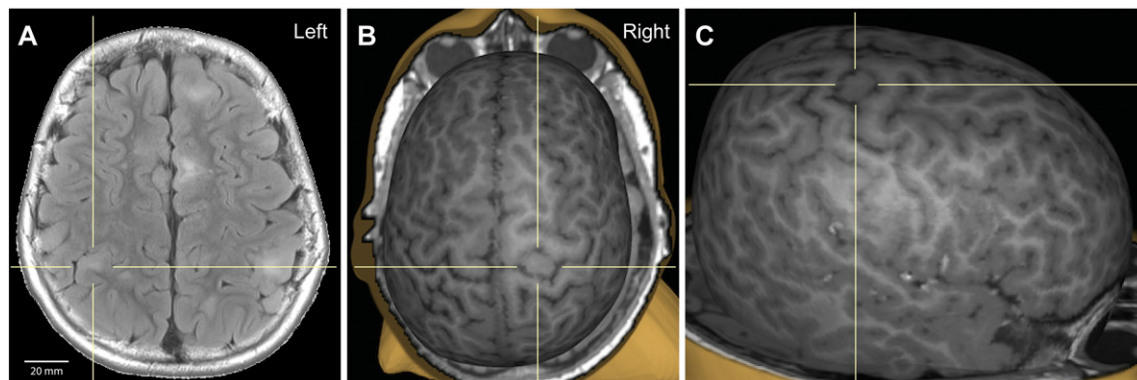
(A) Axial fluid-attenuated inversion recovery (FLAIR) image, with 20 mm scale-to-size reference. (B and C) 3D MRI reconstruction of the cortical surface with superior (B) and right (C) view. The crosshairs in all panels indicate the cortical tuber.
